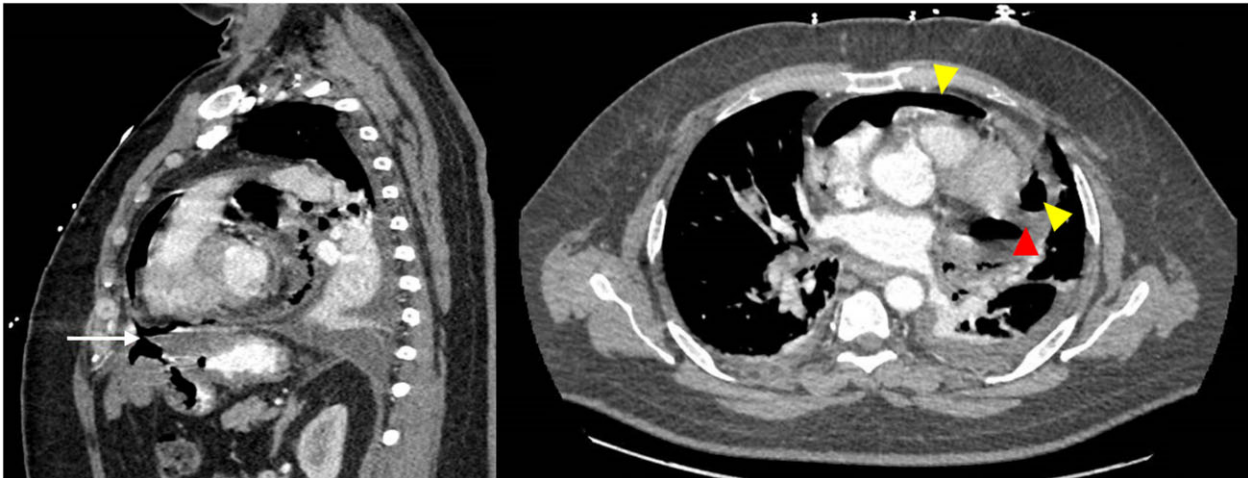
Sagittal and axial views of the admission chest computed tomography. The white arrow on the sagittal view demonstrates the fistulae between the gastrojejunostomy and the pericardium. The yellow arrowheads on the axial view demonstrate gas, whilst the red arrowhead demonstrates a locule of the pericardial effusion.
